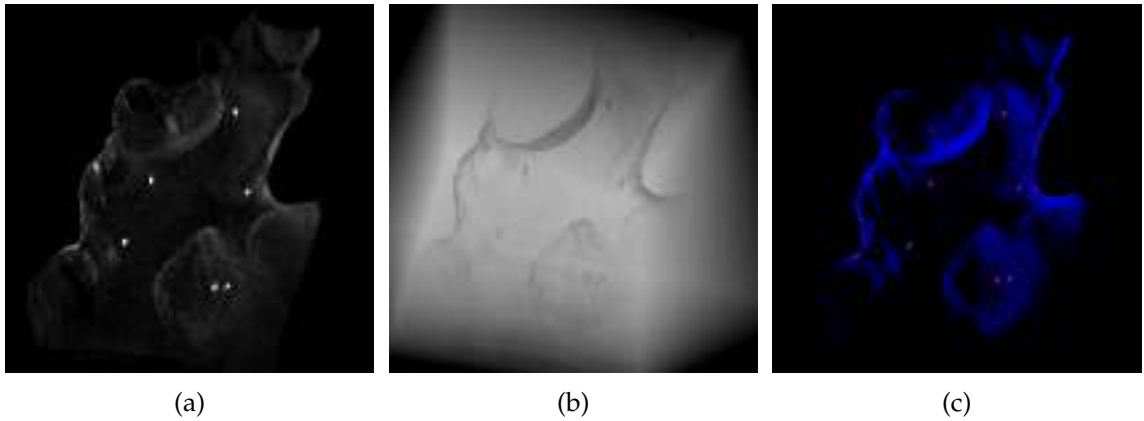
Examples of synthetic X-Ray with different emphasis.
